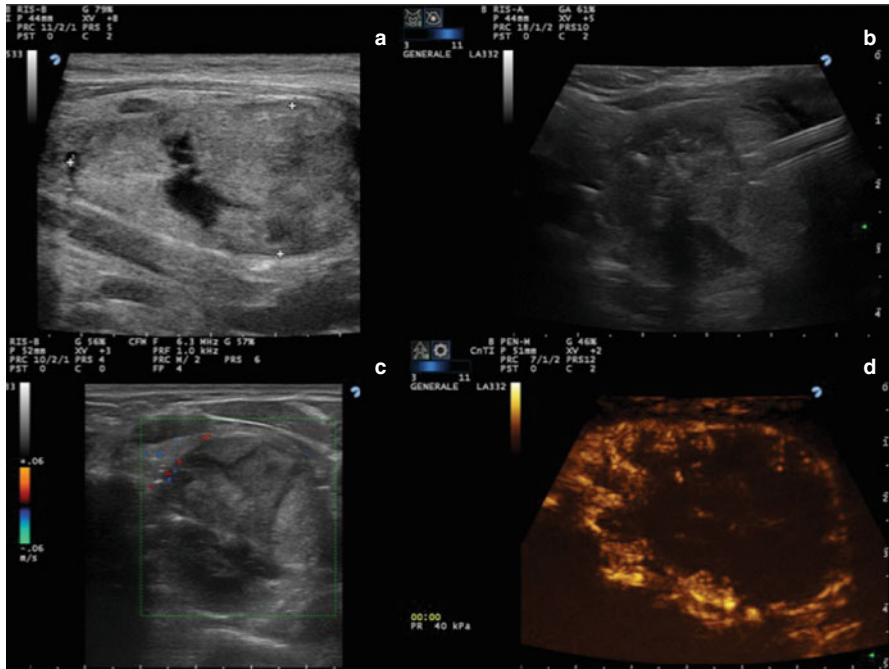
(a) Ultrasound scan of a large, prevalently solid, cold thyroid nodule (DM $4.6 \times 2.3 \times 3.7$ cm vol 20.3 cc). (b) Under ultrasound monitoring, two optical fibres are inserted into the nodule and start laser firing. (c) After 600 s of energy delivery, colour-Doppler examination of the target lesions demonstrates a large area of thermal necrosis devoid of vascular signals. (d) Contrast-enhanced ultrasound, performed 24 h after treatment, clearly depicts a large area of tissue ablation with no evidence of blood supply
